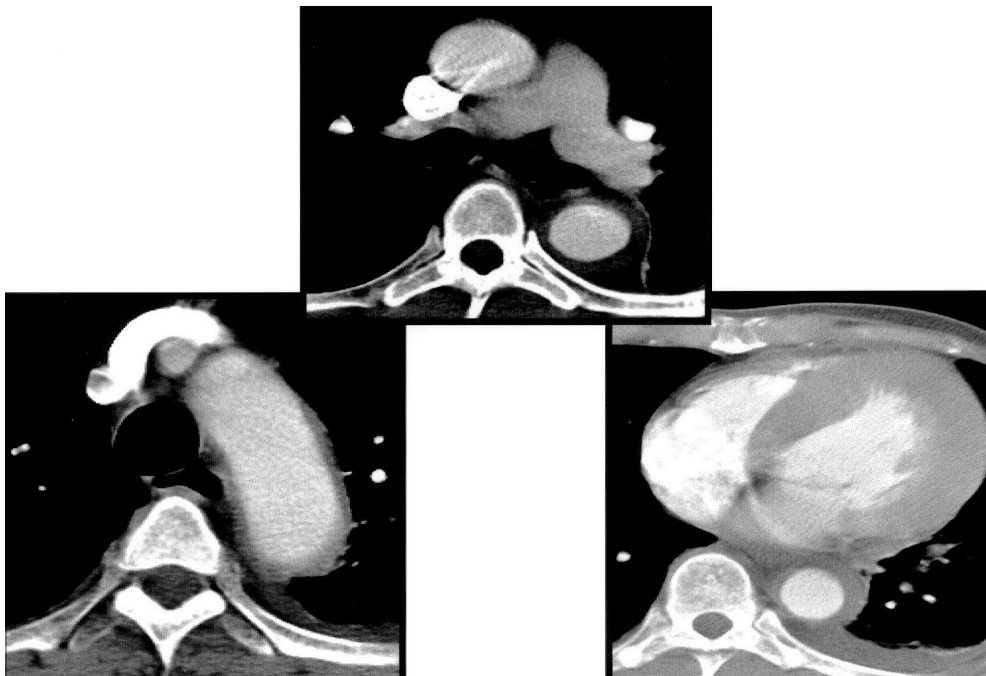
Computed tomography scan with contrast enhancement demonstrated intramural hematoma extending from aortic arch to thoracic descending aorta.
